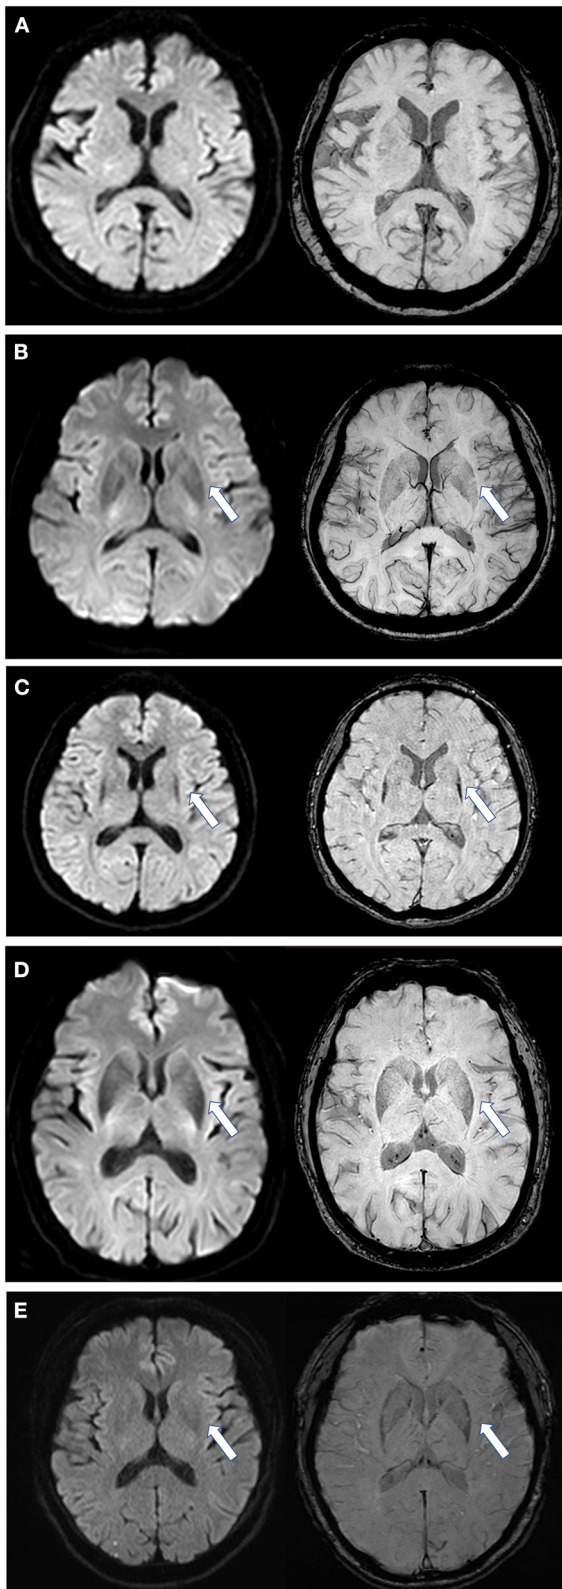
Scores of putaminal hypointensity in DWI and the corresponding SWI sequence. Left, DWI sequence; right, SWI sequence. (A) DWI and SWI (Continued)
